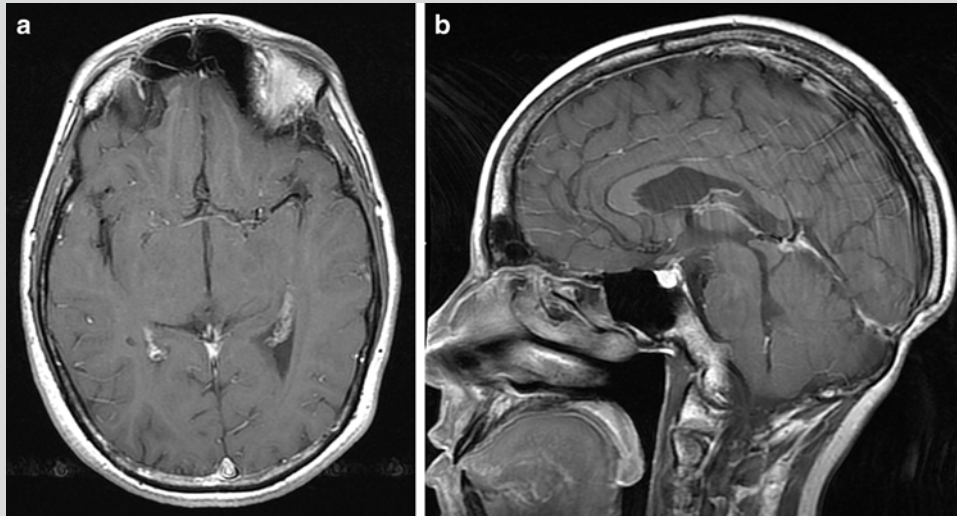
A 12-year-old boy presented with hydrocephalus secondary to pineal region NGGCT. Axial (a) and sagittal (b) gadolinium-enhanced MRI demonstrating complete of response of pineal region NGGCT 6 years after GKRS boost to craniospinal irradiation
